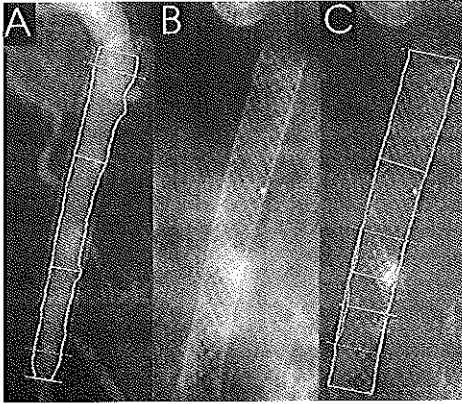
"Magic" Wallstent at 6-month follow-up. Note the excellent definition of the stent boundaries outside the opacified lumen (A). The high radiographic visibility on contrast-free angiograms (B) permits reliable QCA analysis of the stent dimensions (C).
